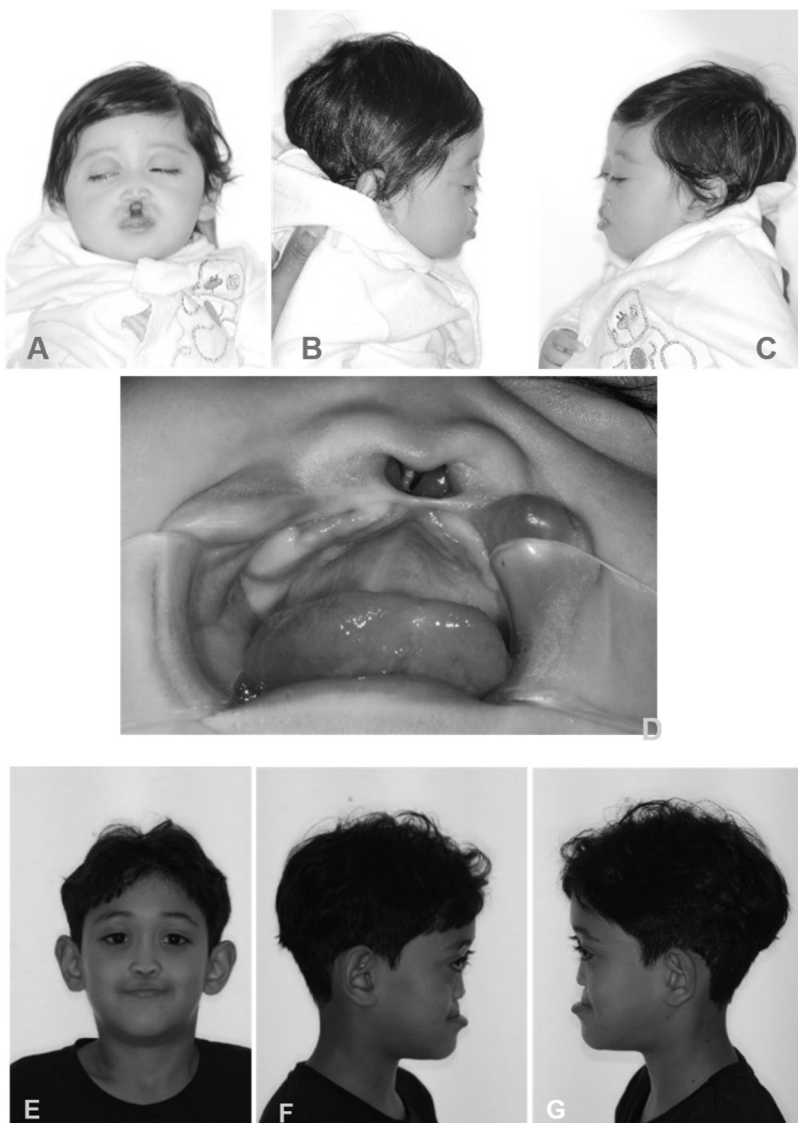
Clinical phenotype of a male patient with Sakoda complex (OMIM 610871). A-D: at three months old, a short nose with a wide and depressed nasal base, large columella and midline cleft lip extending through vermillion and philtrum were observed. A midline cleft palate and basal cephaloceles were present in the oral cavity. E-G: postoperative follow-up at five years old. Note the orbital hypertelorism and the wide nasal bridge. H: translucent computed tomography 3D reconstruction showing a maxillary midline cleft extending until the nasal cavity. I: computed tomography axial section showing a bone defect between the maxillary central incisors. J: periapical radiography showing a wide midline defect in the alveolar ridge between the maxillary central incisors. K-O: computed tomography 3D images obtained at five years old.
